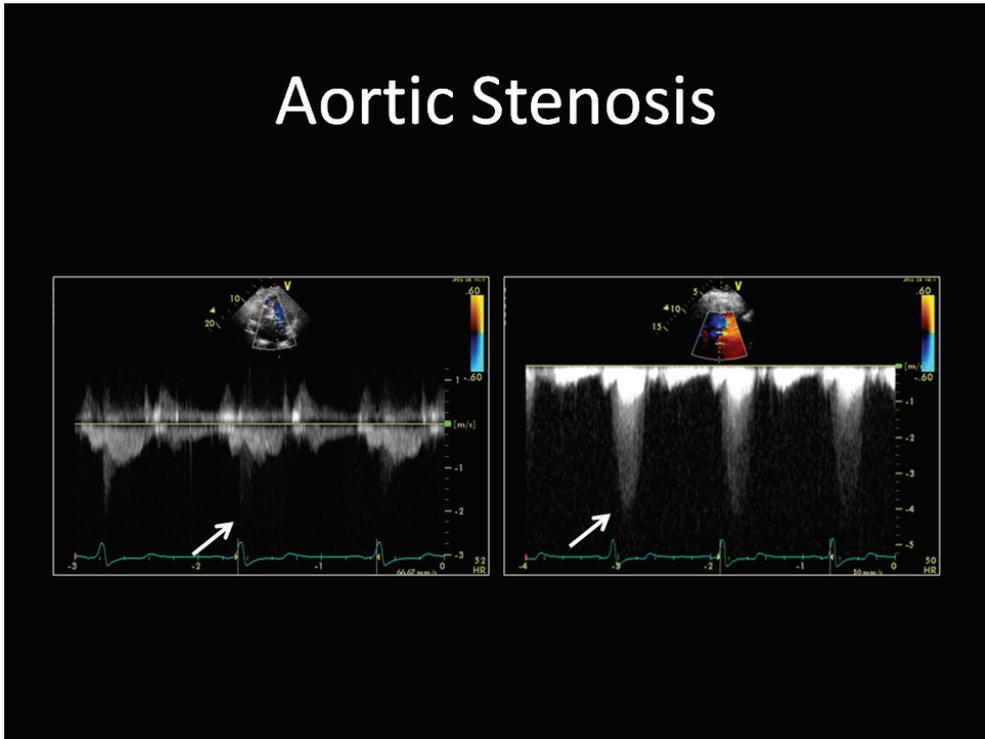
Continuous wave spectral Doppler display of a patient with aortic stenosis. Left. Unenhanced image with weak tracing unable to confirm maximal gradient  $>30\text{mmHg}$  (arrow). Right. Contrast enhanced image (same patient as shown on the left) with optimal Doppler tracing confirming a maximal gradient  $>70\text{mmHg}$
